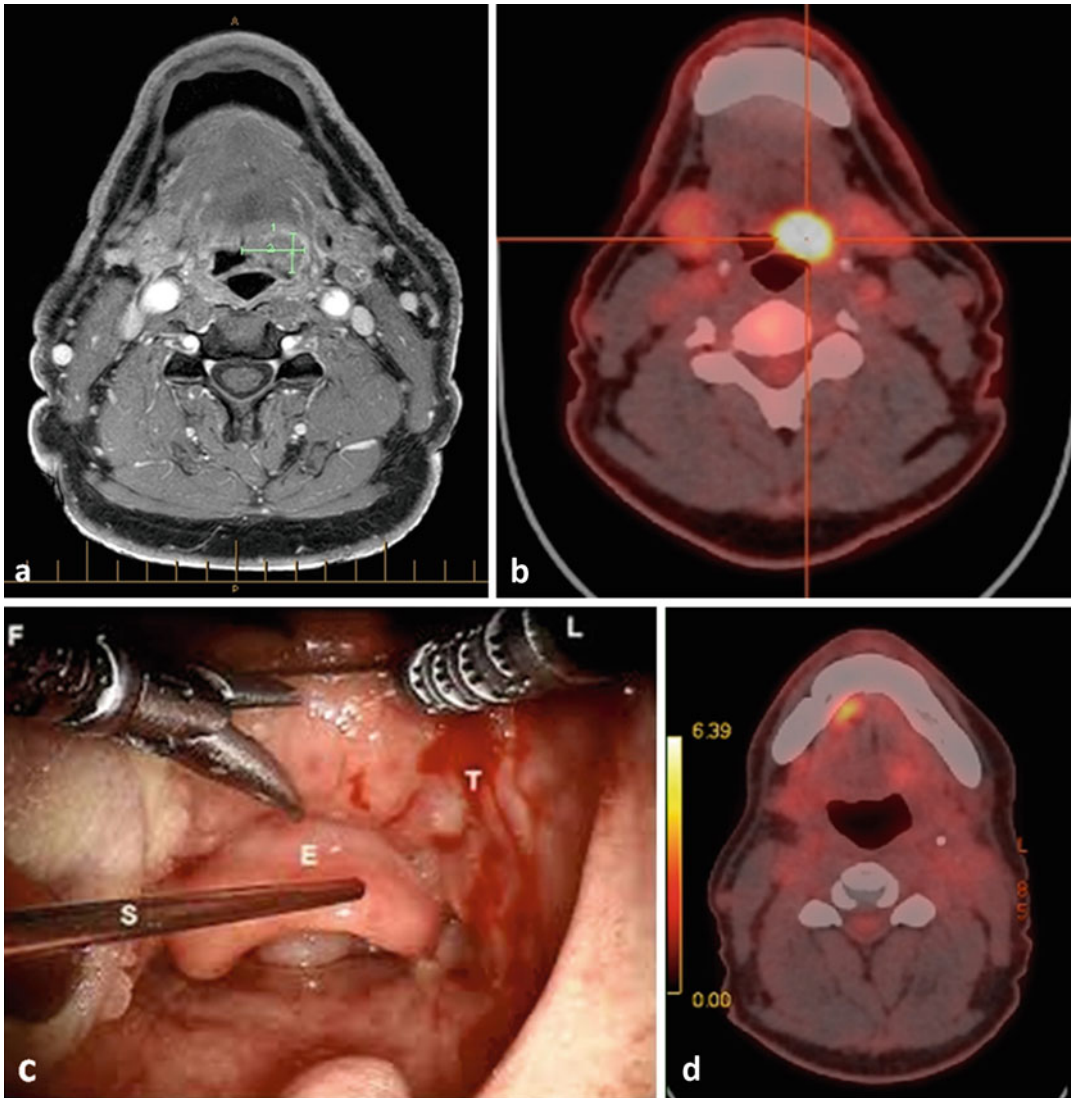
Base of tongue squamous cell carcinoma. MRI (a) shows a well-defined, left-sided tongue base mass measuring 26 mm in its superoinferior dimension with a mediolateral width of 21 mm and a depth of 13 mm. The lesion fills the left vallecula and has a peripheral enhancing margin merging with the normal oropharyngeal and tongue base mucosa. There is no overt invasion of the remainder of the tongue base, the oral tongue, or the oropharynx. The
